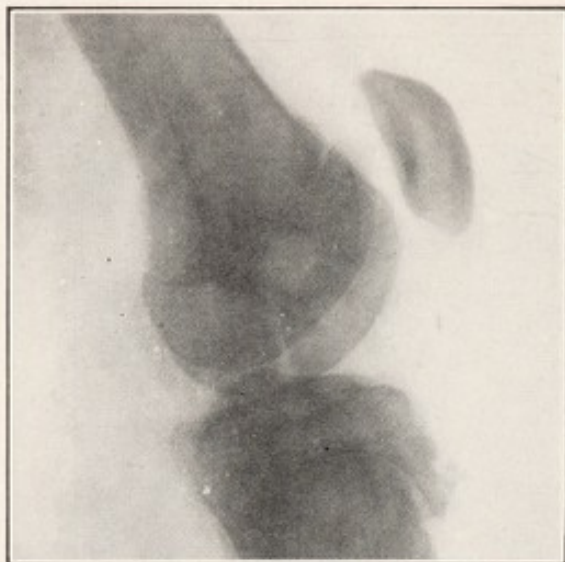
X-RAY SHOWING EPIPHYSITIS OF TIBIAL TUBERCLE.
